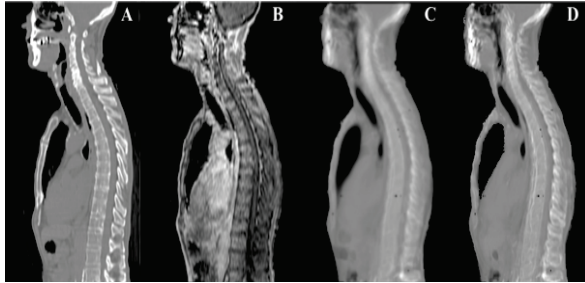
A: Corresponding CT image. B: Target MR image. C: Pseudo-CT Hofmann approach D: Pseudo-CT obtained from SAP approach.
